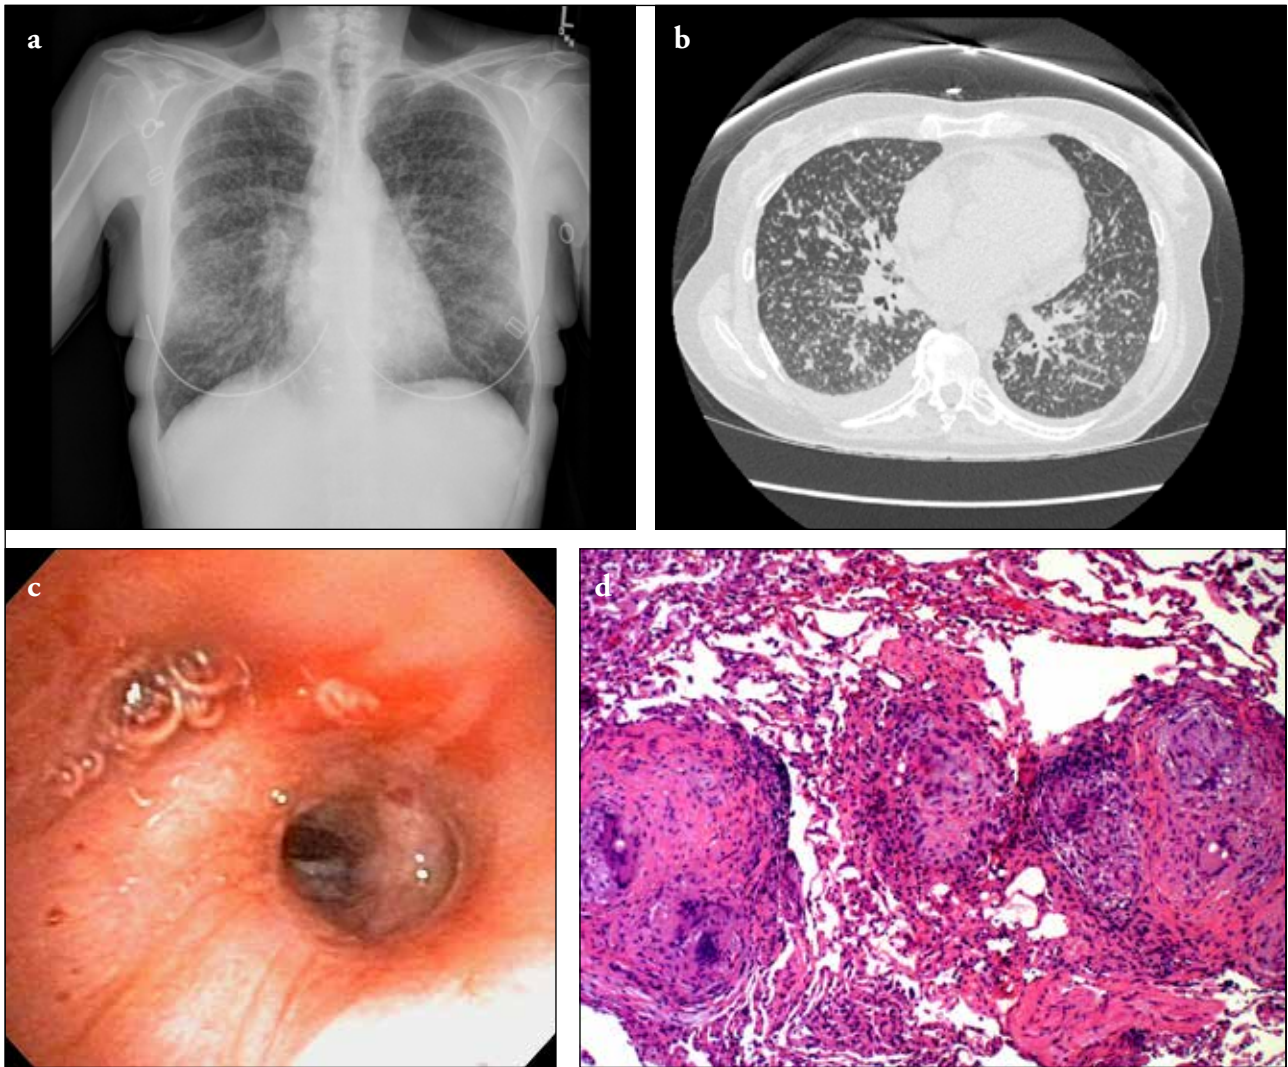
a-d. Chest X-ray showing diffuse nodules and airspace opacities (Panel A). Axial computed tomography showing numerous diffusely spread nodules (Panel B). Bronchoscopy showing non-obstructing raised nodular lesions throughout the tracheobronchial tree (Panel C). Pathological slides showing non-necrotizing granulomas (Panel D)
